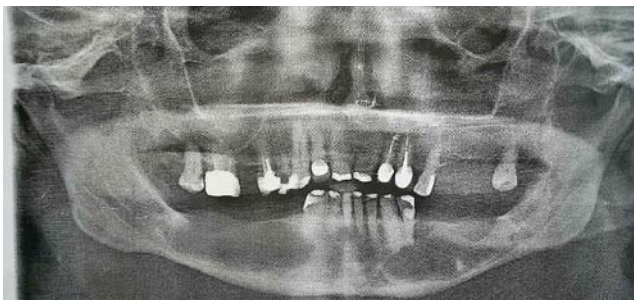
Panoramic radiograph – keratocyst on the left side and radicular cyst of the right side of the mandible
